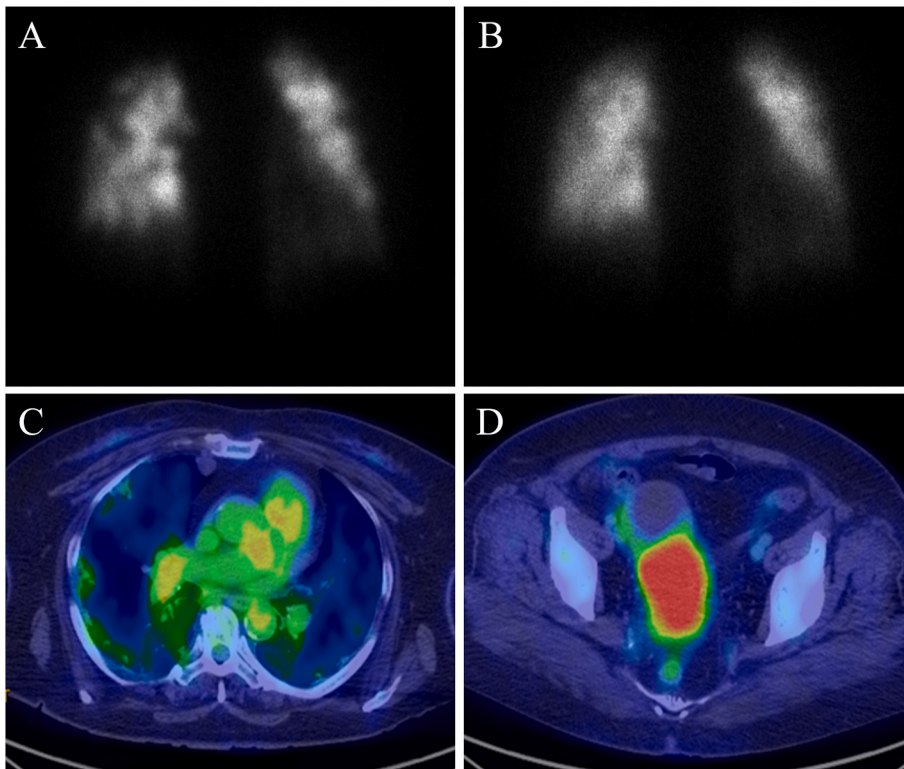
Pulmonary perfusion scintigraphy findings before chemotherapy (A) and after chemotherapy (B). PET-CT findings used to diagnose uterine cervical cancer (C–D). Pulmonary perfusion scintigraphy showing multiple small peripheral perfusion defects in both lungs (A). The defects are improved after chemotherapy (B). PET-CT revealing FDG accumulation with consolidation in both lungs (C) and in the uterine cervix (D). PET-CT: Position emission tomography-computed tomography, FDG: Fluorodeoxyglucose (¹⁸F).
